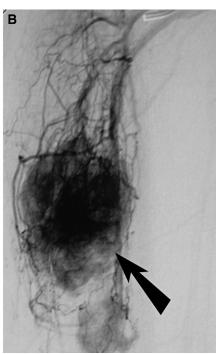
(A) A 50-year-old man with history of nephrectomy for renal cell carcinoma 2 years earlier, presented with a mass over the anterior aspect of the lower limb. T2-weighted magnetic resonance imaging, axial reconstruction, showing high signal mass within the tibialis anterior muscle (white arrow). Biopsy confirmed recurrence of this patient's original renal tumour. (B) Spot image from lower limb angiography in the same patient, demonstrating the hyper-vascularity of this tibialis anterior based renal cell carcinoma metastasis (black arrow).
